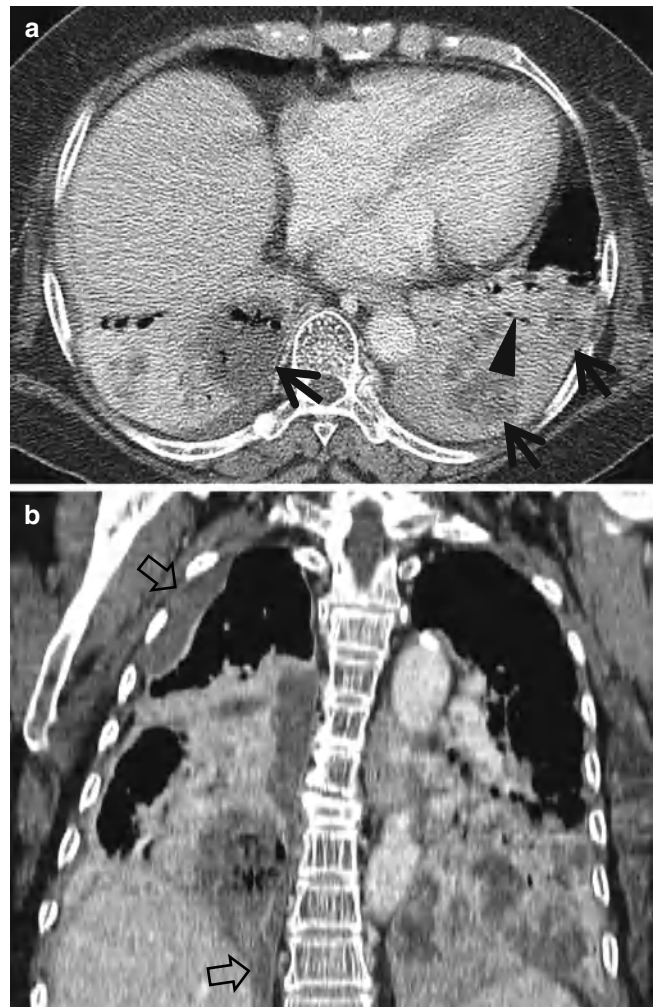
Klebsiella pneumoniae* in a 62-year-old woman. (a) Mediastinal window of enhanced CT scan (2.5-mm section thickness) obtained at level of liver dome shows dense lobar consolidation in both lower lobes containing multifocal areas of necrotic low-attenuation areas (arrows). Also note CT air-bronchogram signs (arrowhead) within consolidative lesions. (b) Coronal reformatted image demonstrates necrotic lobar consolidation involving both lower lobes. Also note right pleural effusion (open arrows)
